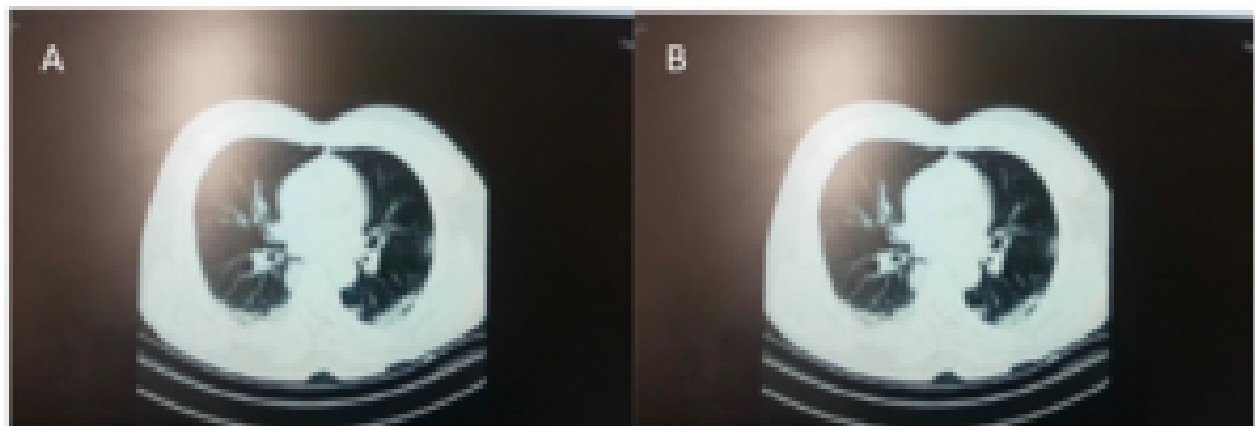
Lung high-resolution computed tomography.¹
